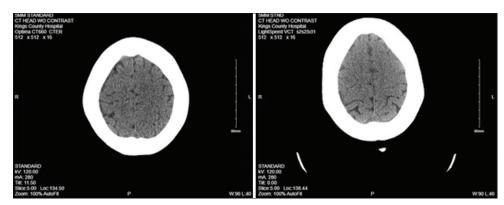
Initial CT head showed no acute intracranial pathology (left). Repeat CT head showed nonspecific, mild sulcal effacement in the bilateral high frontal lobes, which can be seen in meningitis (right). CT: Computed tomography. Source: Zachary Mostel, MD, Department of Medicine, NYC Health and Hospitals/Kings County Hospital Center, Brooklyn, NY, USA
